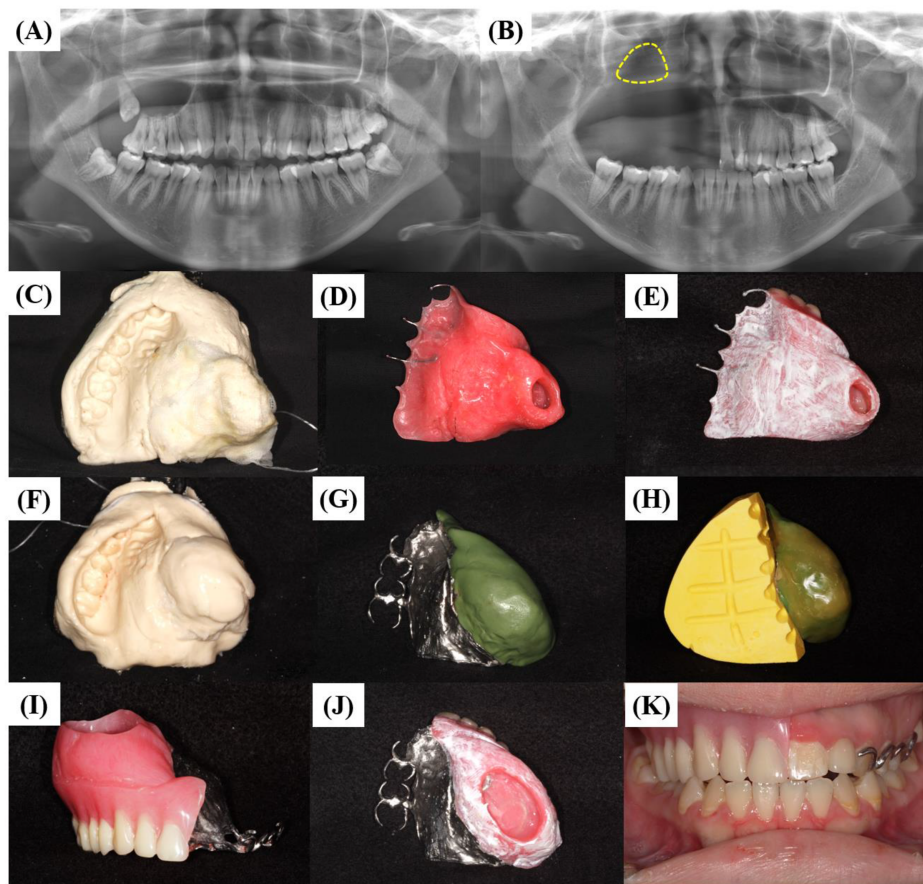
The process of creating an obturator. (A) Panoramic radiograph before ameloblastoma treatment. (B) Panoramic radiograph after ameloblastoma excision. The yellow area indicated the defect site. (C) Initial impression procedure. (D) Tissue surface view of the temporary obturator. (E) Intraoral follow up evaluation of the temporary obturator. (F) Initial impression of the permanent obturator. (G) Secondary impression procedure performed with a metal framework. (H) Tissue surface of the replaced stone model. (I) Labial view of the definitive obturator removable partial denture fabricated with a new tissue surface. (J) Intraoral follow up of the permanent obturator. (K) Final intraoral view of the permanent obturator after installation.
